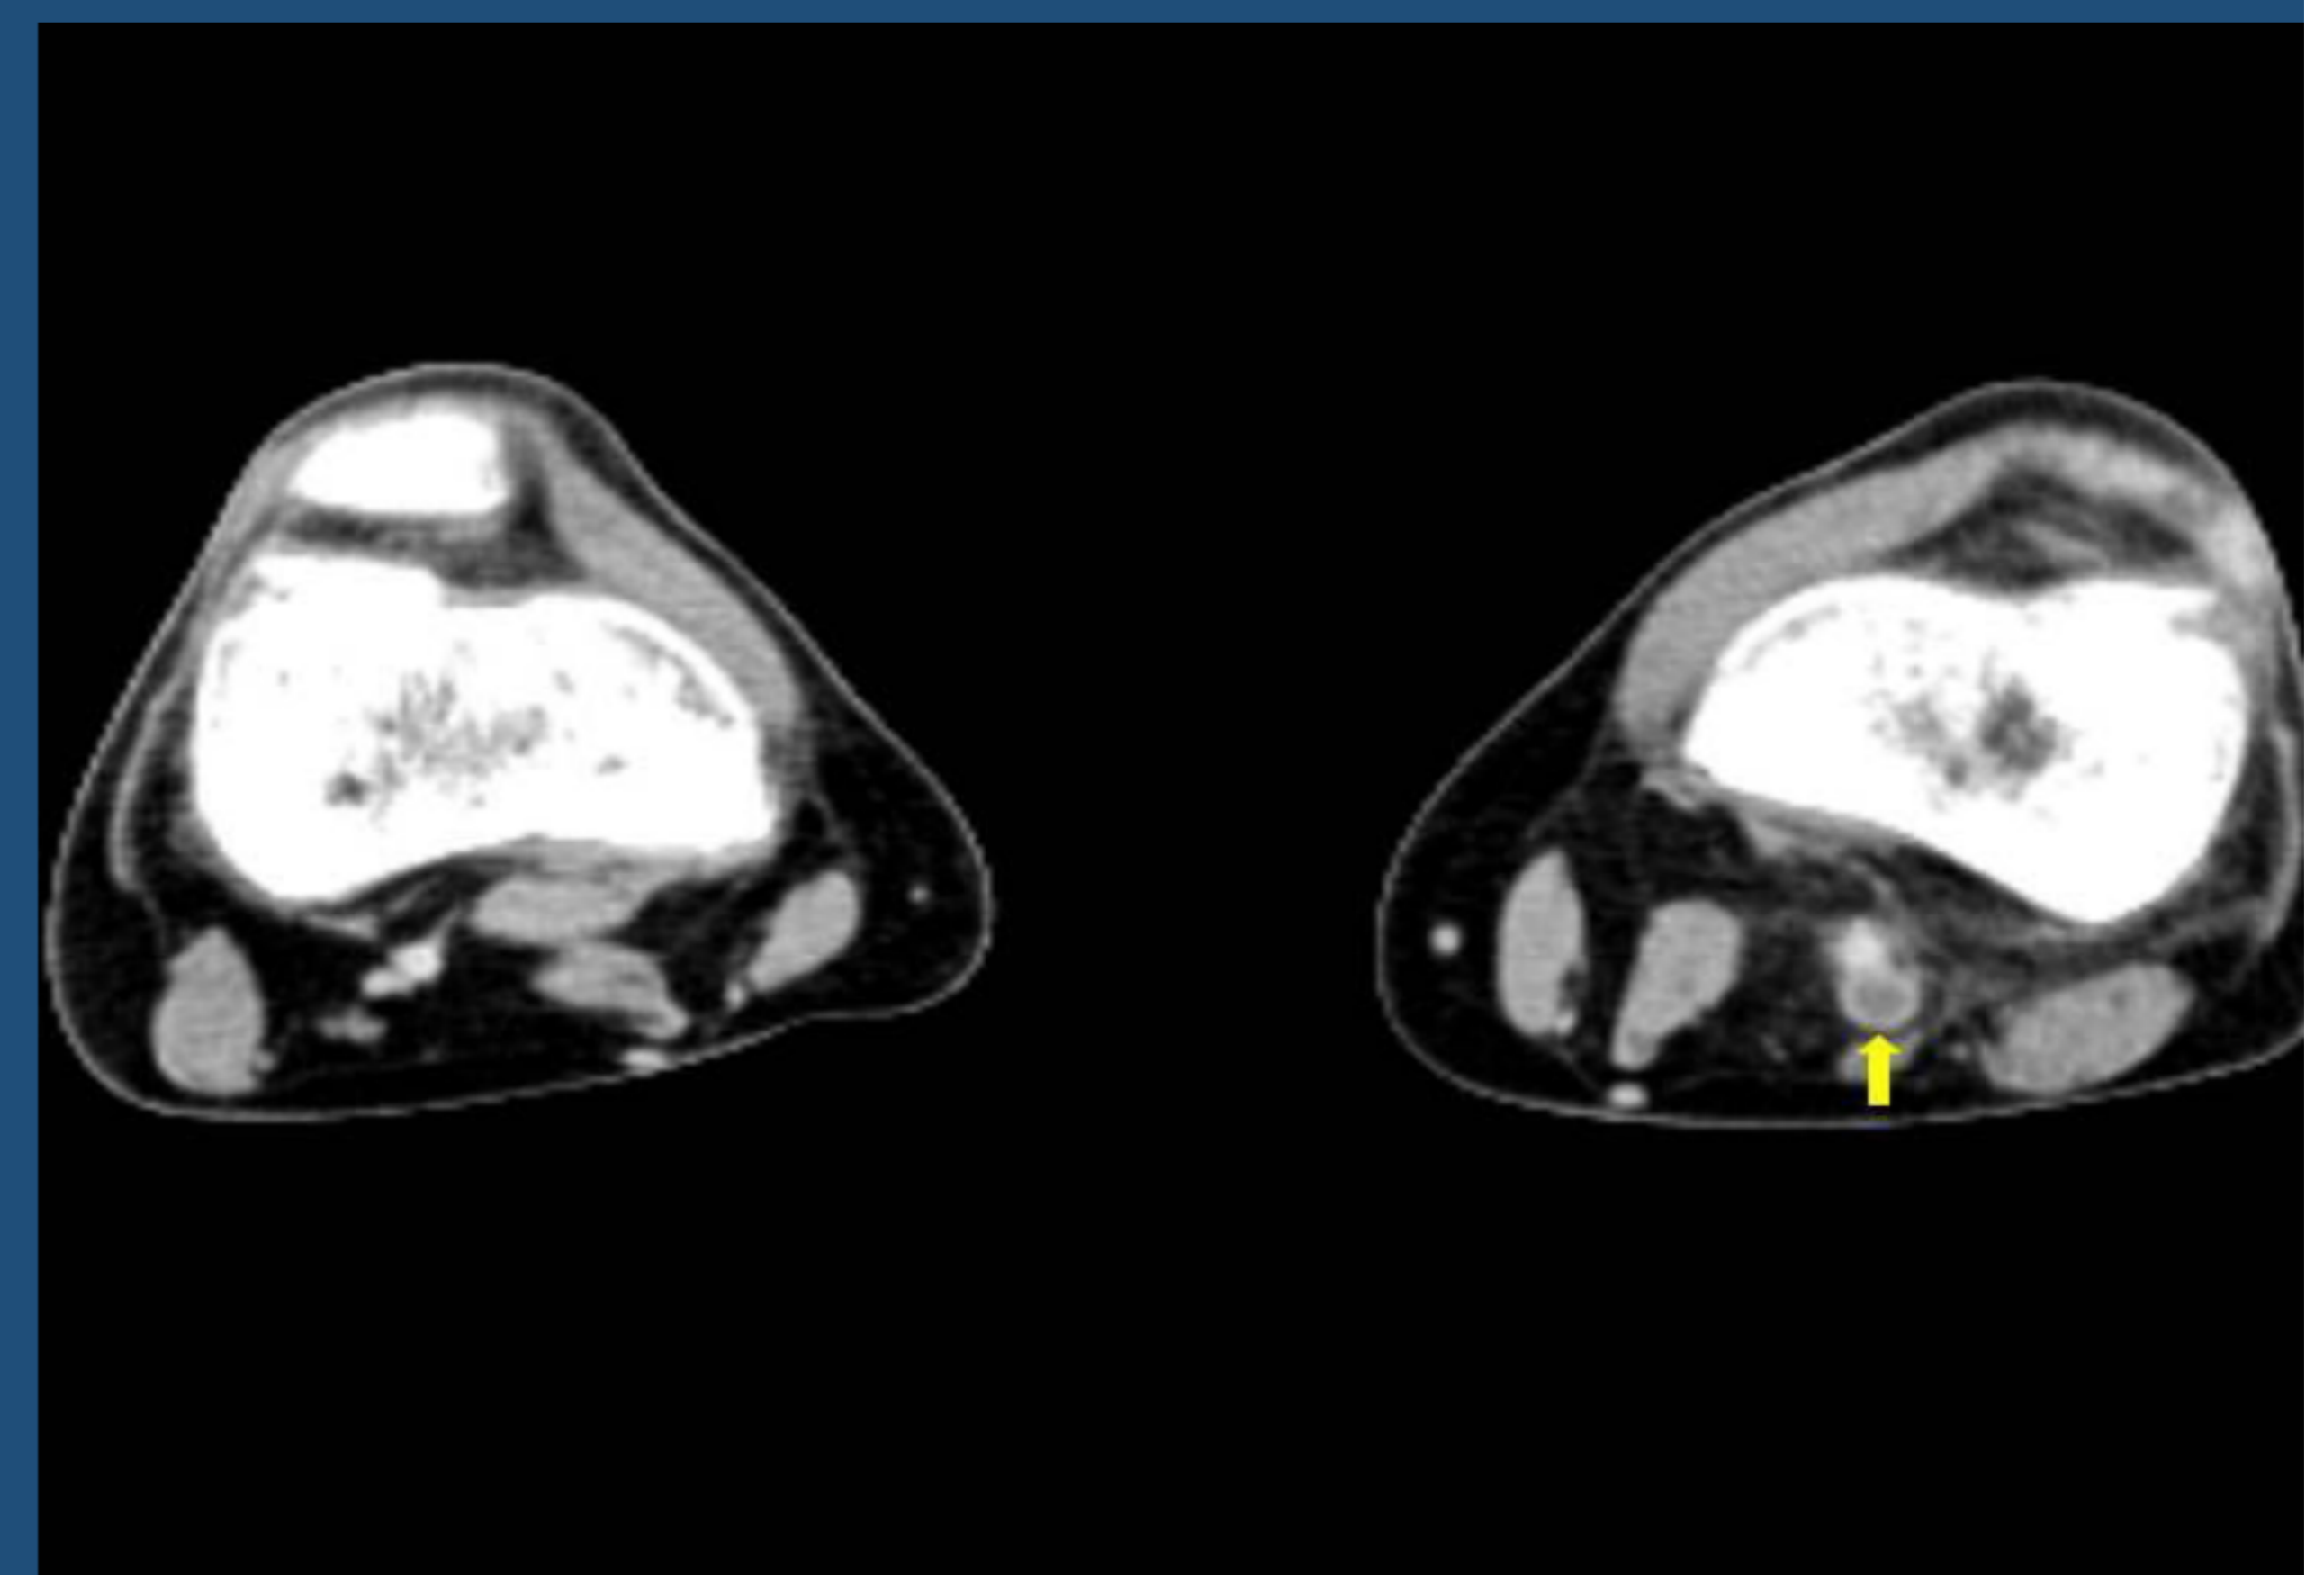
Angio-CT (axial view): left popliteal vein thrombosis with edematous infiltrated adjacent fat
